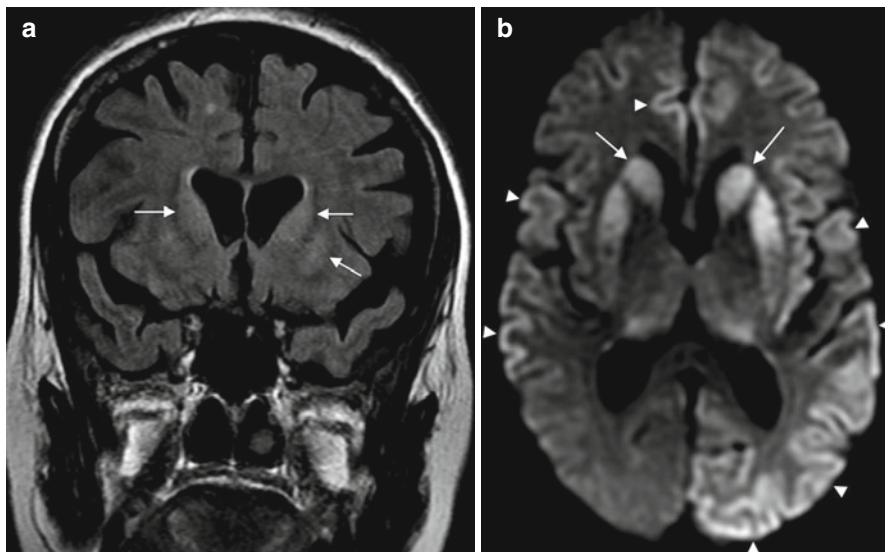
Creutzfeldt-Jacob Disease (CJD). (a) Subtle hyperintensity in the basal ganglia on a coronal FLAIR image (*arrows*). (b) Marked hyperintensity on DWI in the basal ganglia (*arrows*) and extensive areas of cortex throughout the cerebral hemispheres (*arrowheads*)
